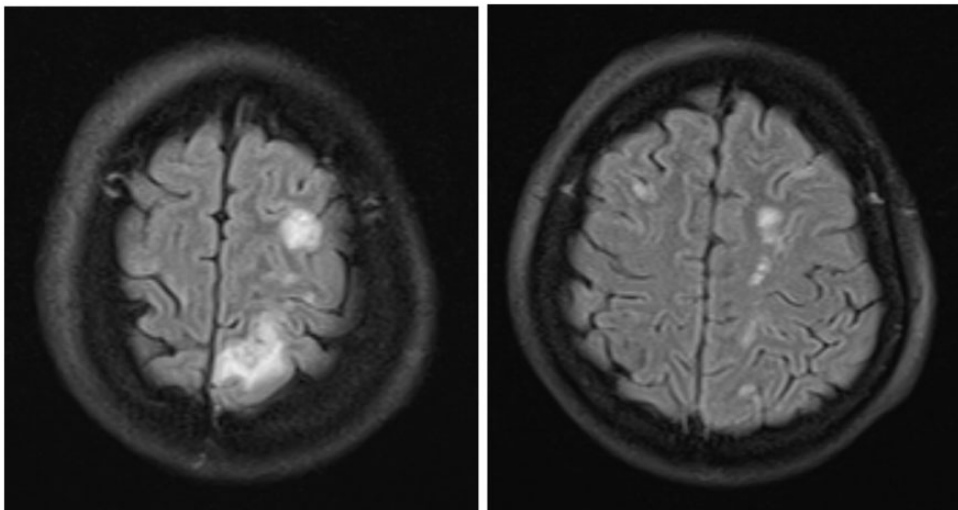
T2-weighted cranial MRI scans showing multiple small infraction lesions in bilateral frontal lobes, left parietal lobe and occipital lobe.
